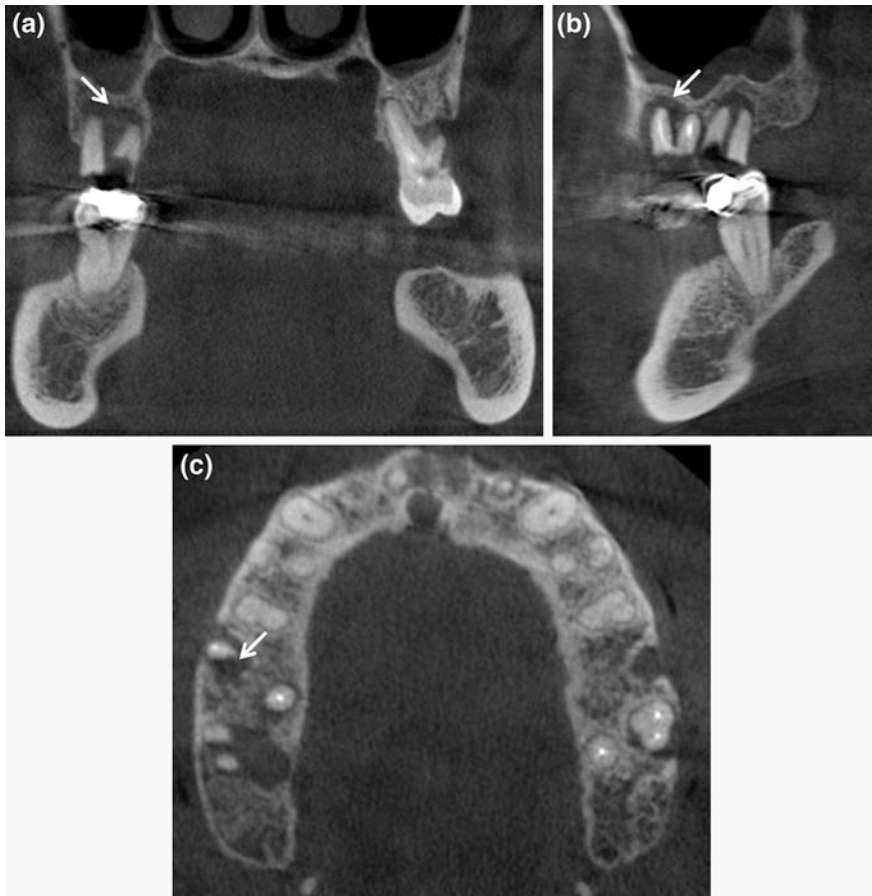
CBCT coronal (a), sagittal (b) and axial (c) sections showing a wide radiolucent periradicular area dependent to the element 16 surrounding the mesial root (*thin arrow*). The radiographic signs suggest periradicular periodontitis
